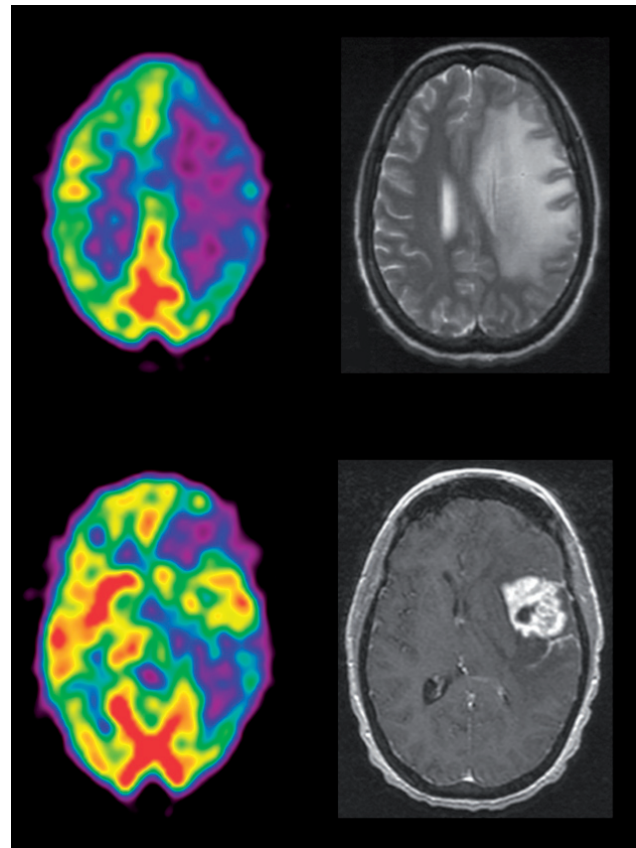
A patient with active tumor and extensive edema. ^{18}F -FDG-PET (left sided column) demonstrated hypermetabolism in the tumor and hypometabolism at the site of edema on the MRI images (right sided column).
